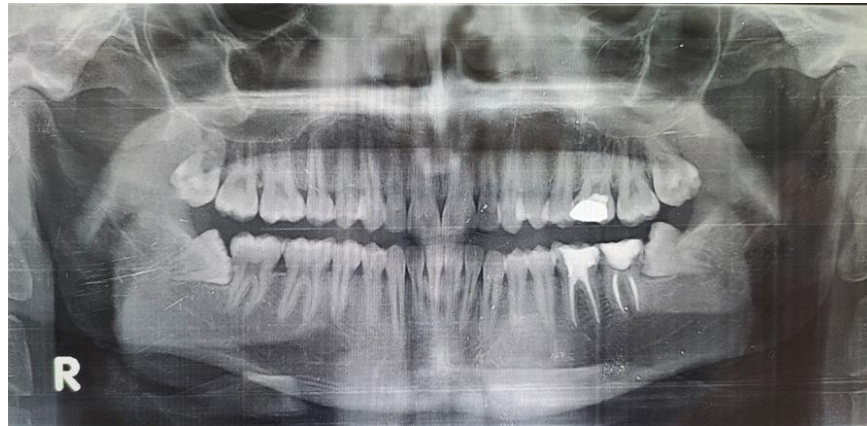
Preoperative radiograph shows impacted teeth of the patient
